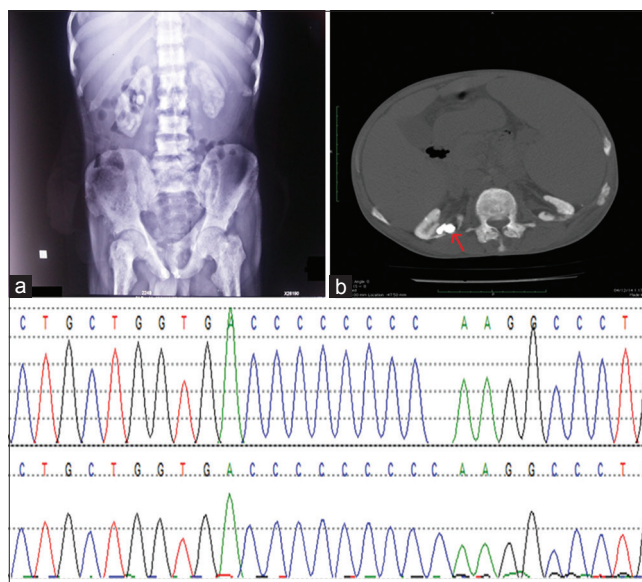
Upper panel - X-ray kidneys-ureters-bladder showed bilateral nephrocalcinosis with varying size stones within (a). Axial computed tomography scan image in bone window showed bilateral cortical nephrocalcinosis, oval-shaped calculi are seen within (b). Lower panel - DNA sequence chromatograms of the patient showing c. 33dupC mutation in the *AGXT* gene
